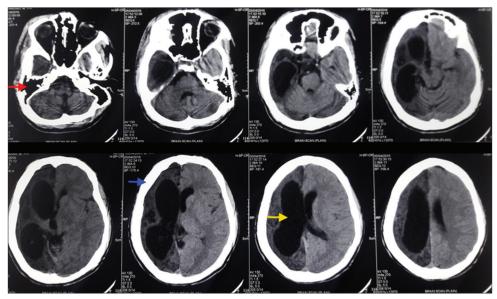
Computed tomography scan showing enlargement of right ethmoid sinus, mastoid air cells (red arrow), calvarial thickening (blue arrow) right hemispheric volume loss and gliosis, and right lateral ventricle dilatation (yellow arrow)
